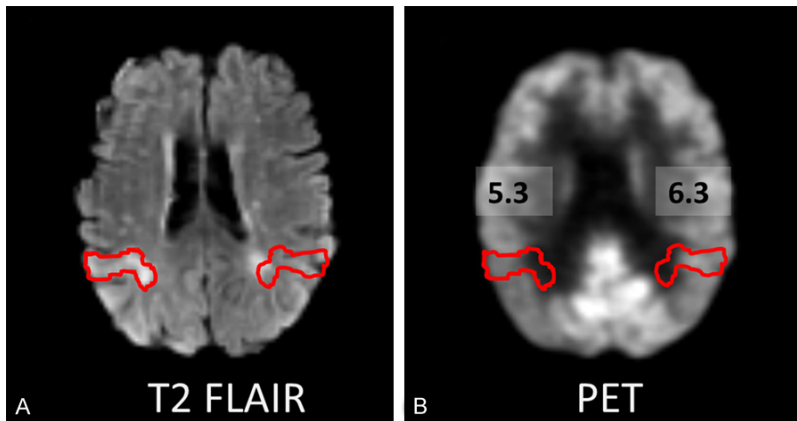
A: A 58-year-old male patient (case 4) with tuberous sclerosis shows an abnormal cortical tuber in right parietal lobe on T2 FLAIR image. B: The co-registered FDG-PET and MRI image shows that this lesion has lower SUV (SUV=5.3) than contralateral homologous cortical region (SUV=6.3).
